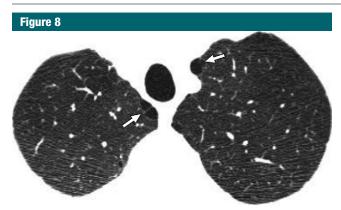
Mild PSE. CT scan in smoker without COPD shows subpleural foci of low attenuation separated by intact interlobular septa along the mediastinum (arrows), measuring less than 1 cm.
